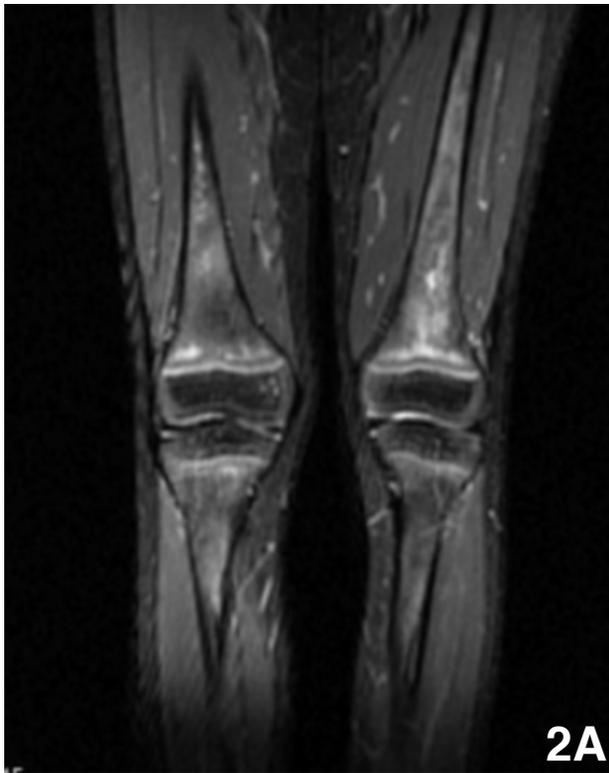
Coronal STIR (TR 3900, TE 44) MR image demonstrates the known, treated femoral lesions as well as new abnormal patchy hyperintense signal within the distal femora and proximal tibiae, especially along the physes.
